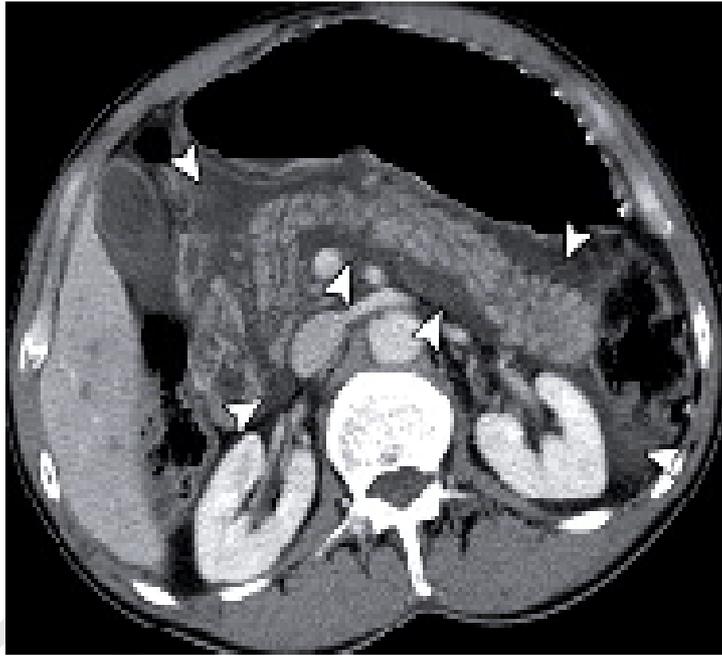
Abdominal CT scan (Retroperitoneal fluid without retroperitoneal organ injury) shows fluid within the anterior pararenal space (arrowheads) diffusely surrounding the pancreas. ⁽⁸¹⁾
